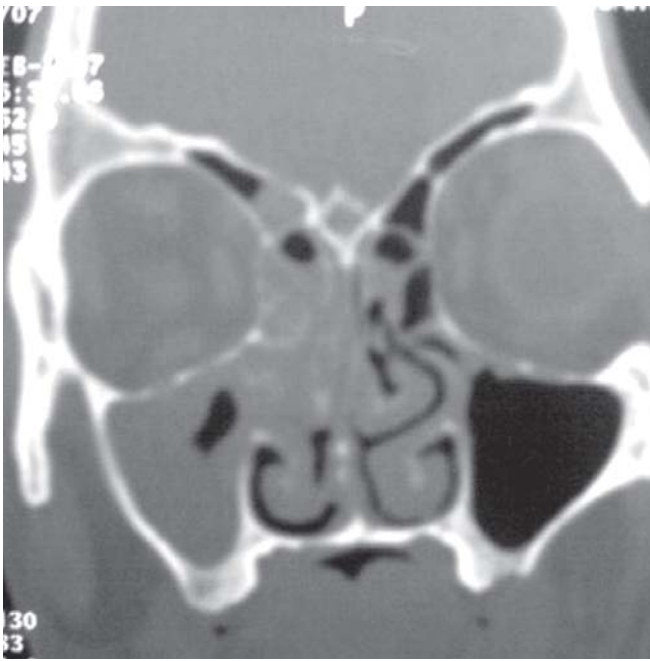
Coronal CT picture of invasive fungal sinusitis
